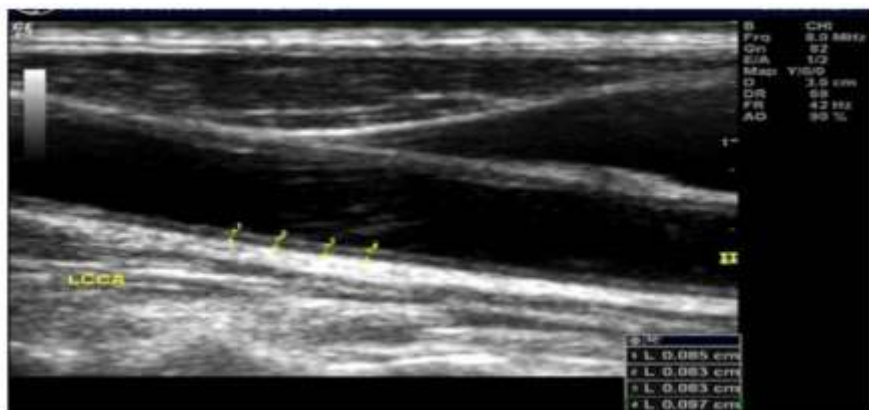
CIMT measurement of carotid intima media thickness by means of M-mode trans thoracic echocardiography, LCCA is the left common carotid artery.^[11]
